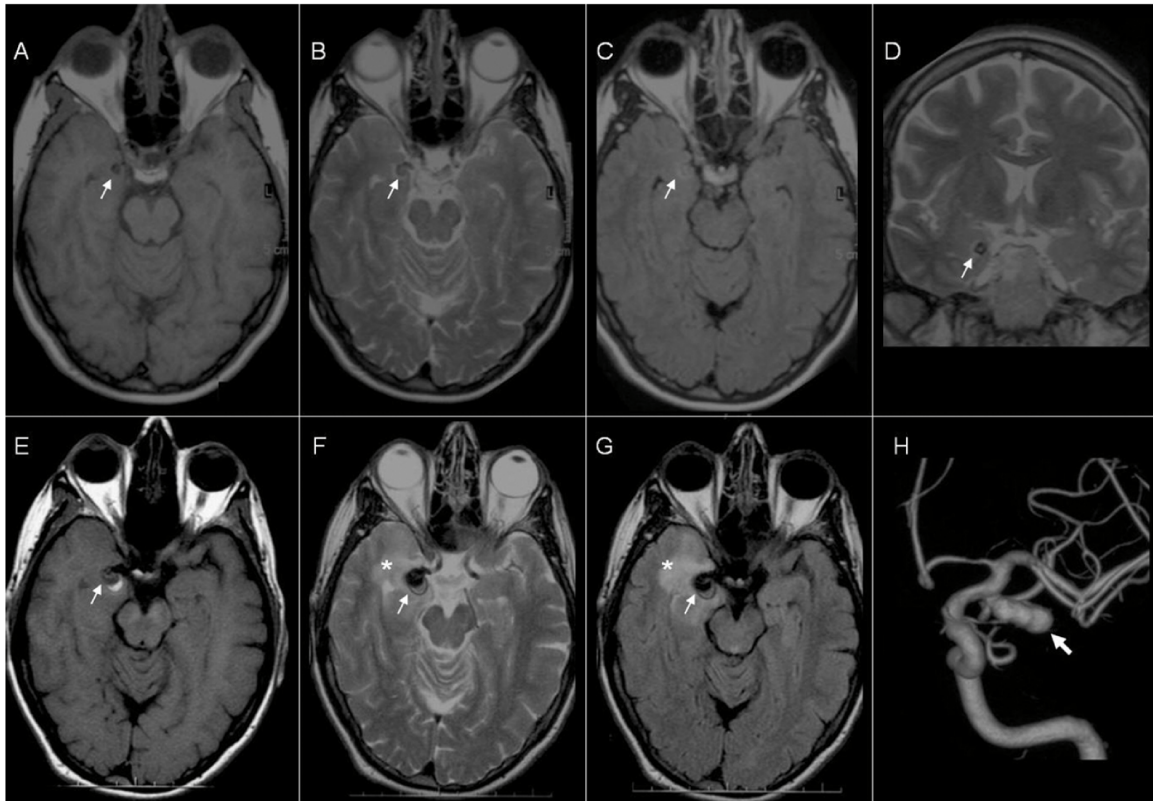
MR imaging (A–G) of brain and MR angiogram (H) of right internal carotid artery. Axial T1-weighted (A), axial T2-weighted (B), axial FLAIR (C), and coronal T2-weighted (D) images depicting a 4-mm right PCOM artery aneurysm (arrows) without temporal lobe edema. Axial T1-weighted (E), axial T2-weighted (F), and axial FLAIR (G) images obtained four years later showing an interval increase to 14 mm in PCOM aneurysm size (arrows) with new mesial temporal lobe edema (asterisks). (H) MR angiogram depicting a multilobed PCOM artery aneurysm (arrow).
